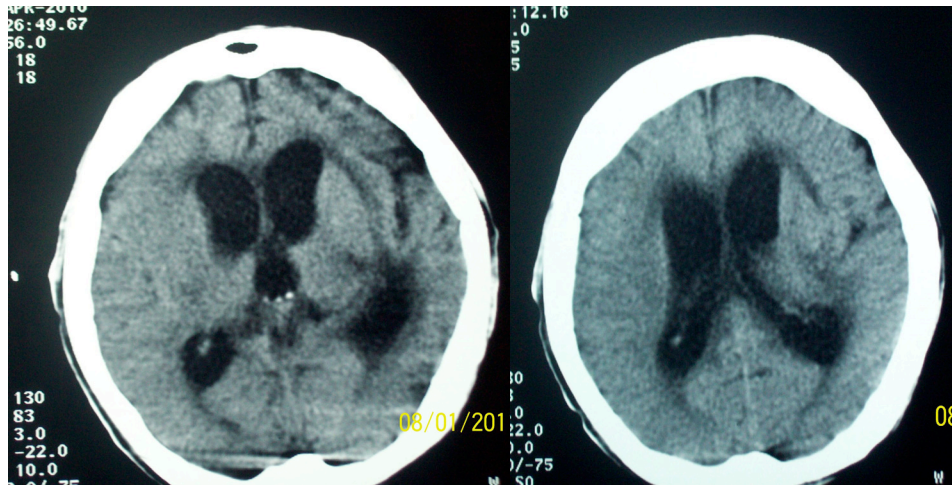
A CT of the brain showing communicating hydrocephalus in the left external capsule, and the posterior limb of the internal capsule.
